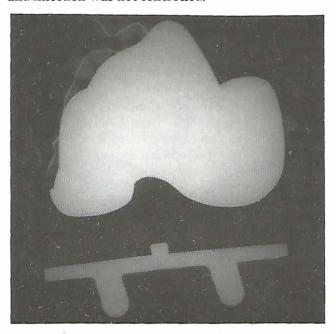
X-rays after antibiotic beads AP view.
